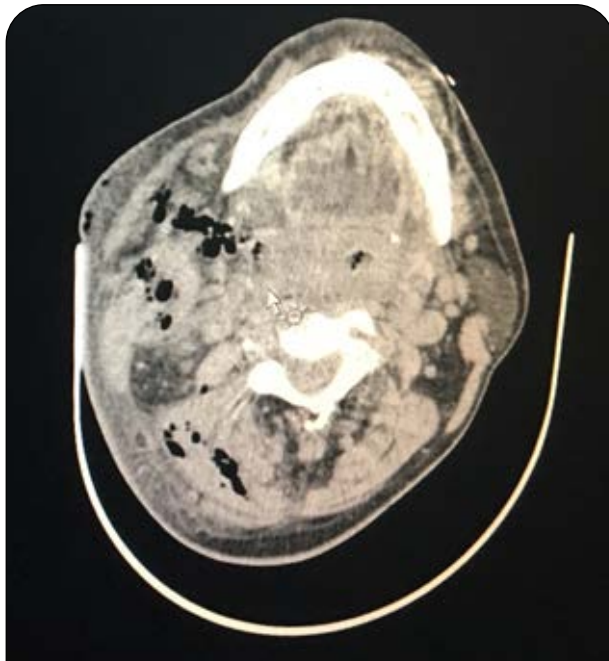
Air bubbles on the simple CT scan showing dissection of the planes and masseteric, pre-vertebral, and vascular spaces' invasion.
